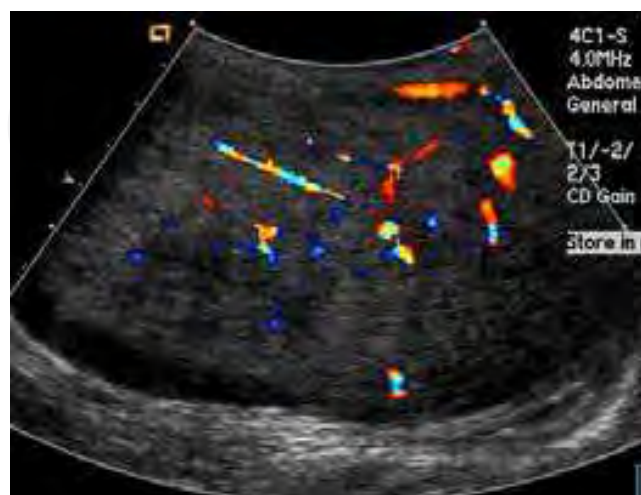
Fibrous pseudotumor. With color Doppler, a little vascular flow is seen in this fibrous pseudotumor
